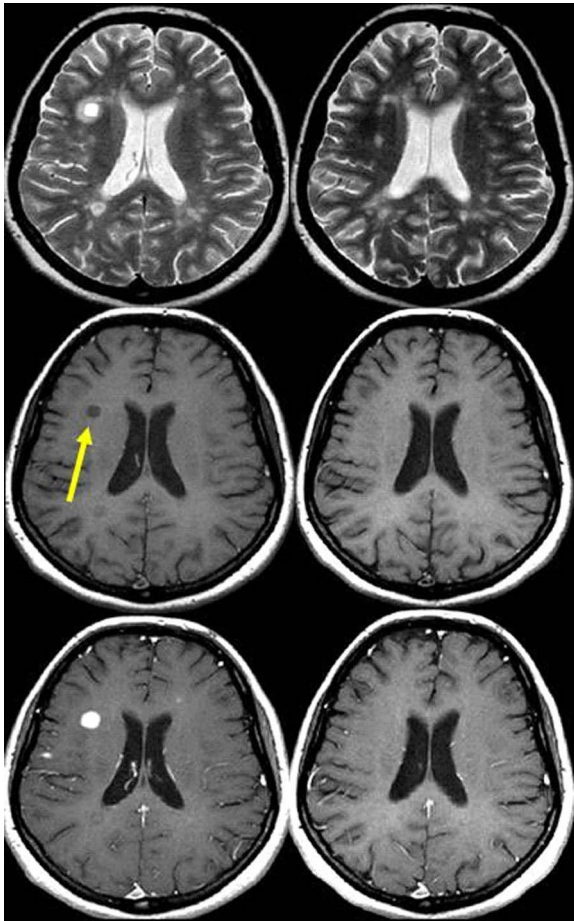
Serial magnetic resonance imaging (MRI) scans obtained in a patient with relapsing–remitting multiple sclerosis. T2-weighted (upper row), unenhanced T1-weighted (middle row), and contrast-enhanced T1-weighted (lower row) MRI scans obtained at baseline (left) and 1 year later (right). Observe the active ‘black hole’ (nodular enhancement) in the subcortical white matter of the right frontal lobe (arrow), which becomes isointense on T1-weighted imaging with cessation of inflammatory activity (no enhancement).
